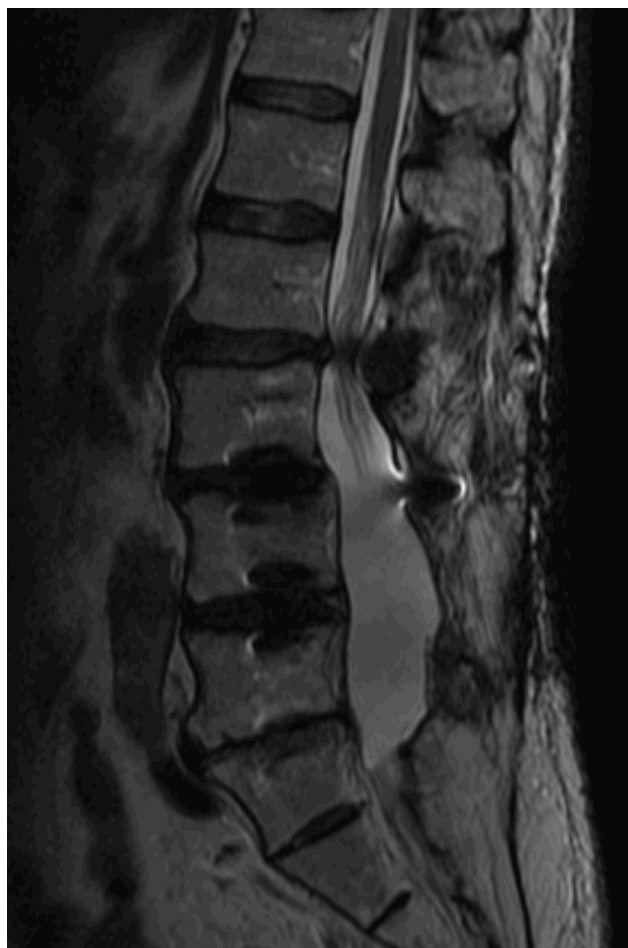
Sagittal T2-weighted image of the lumbar spine.
